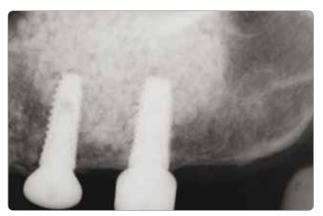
Post-op P.A. radiography after 5 months
